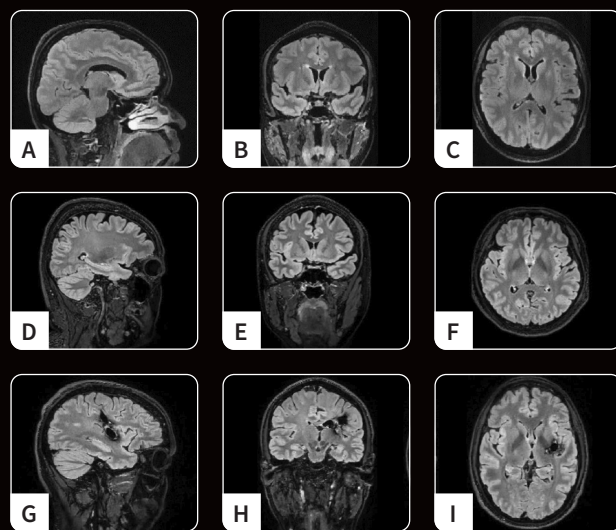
(A-C) A healthy control pre-upgrade. (D-F) Another healthy control post-upgrade. (G-I) A stroke patient post-upgrade with the regions of stroke easily identified in the T2 FLAIR image (inverse contrast compared to T2).
